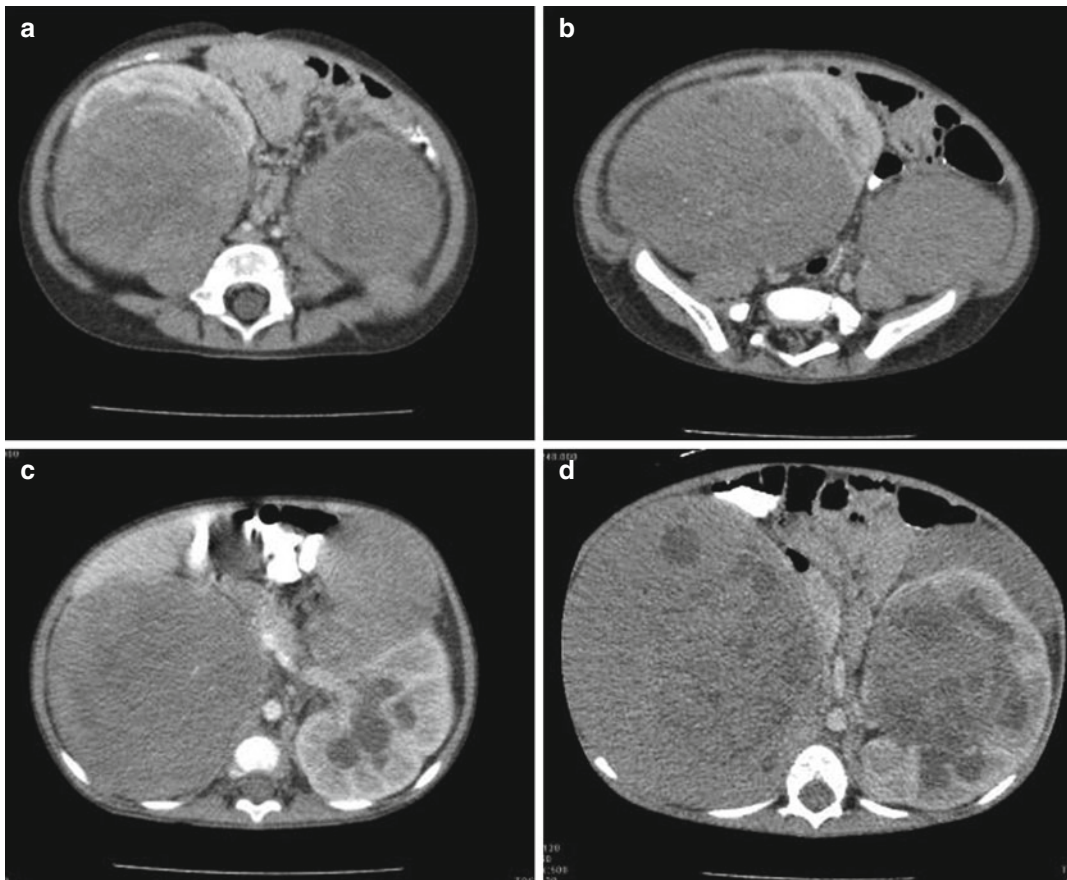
(a, b) Computed tomography scans at presentation of a 1.5-year-old girl with aniridia and bilateral Wilms' tumor. (c, d) Comparison computed tomography
